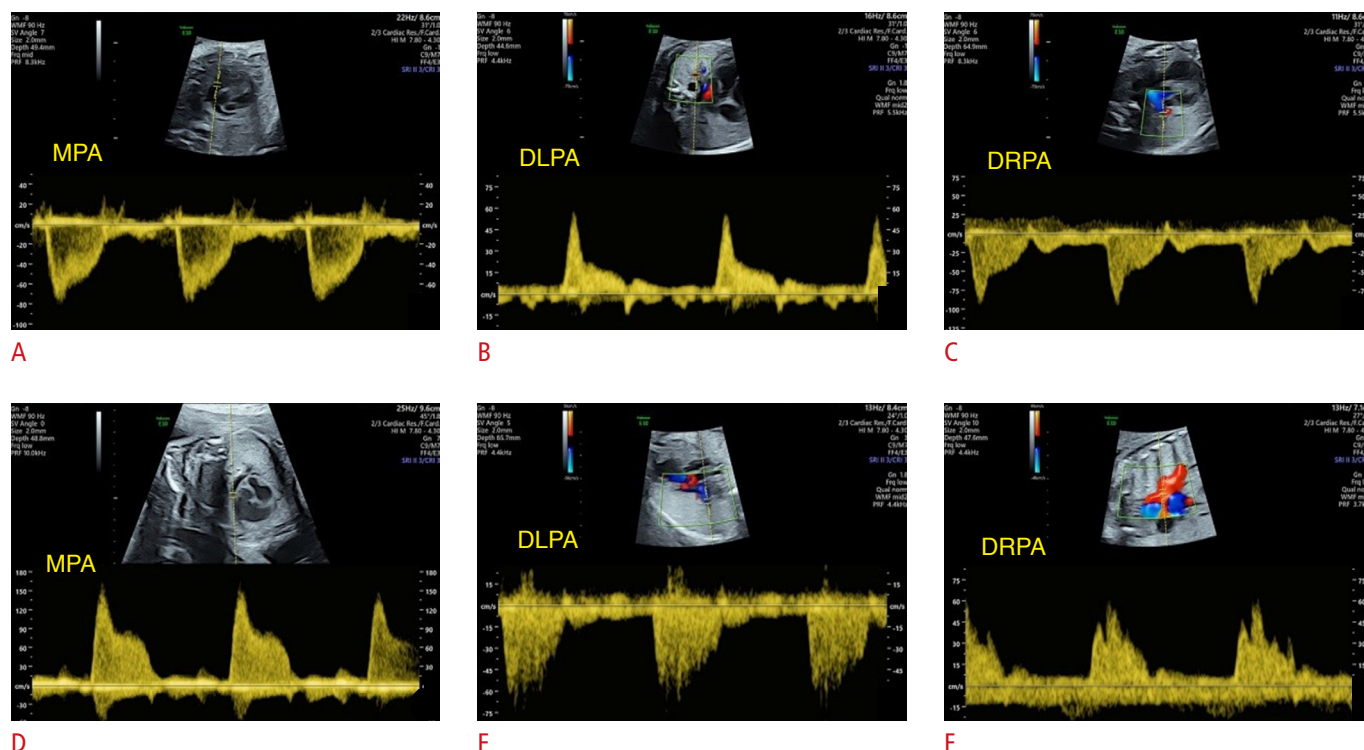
Pulsed-wave Doppler measurements.
